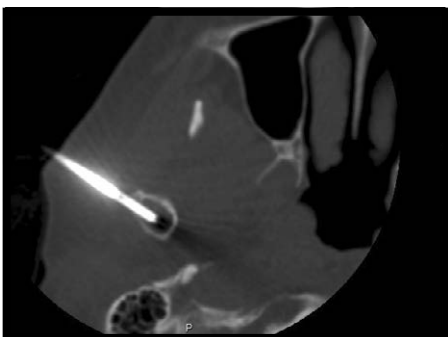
CT guided biopsy of right mandibular condyle lesion with a 13 gauge needle.
